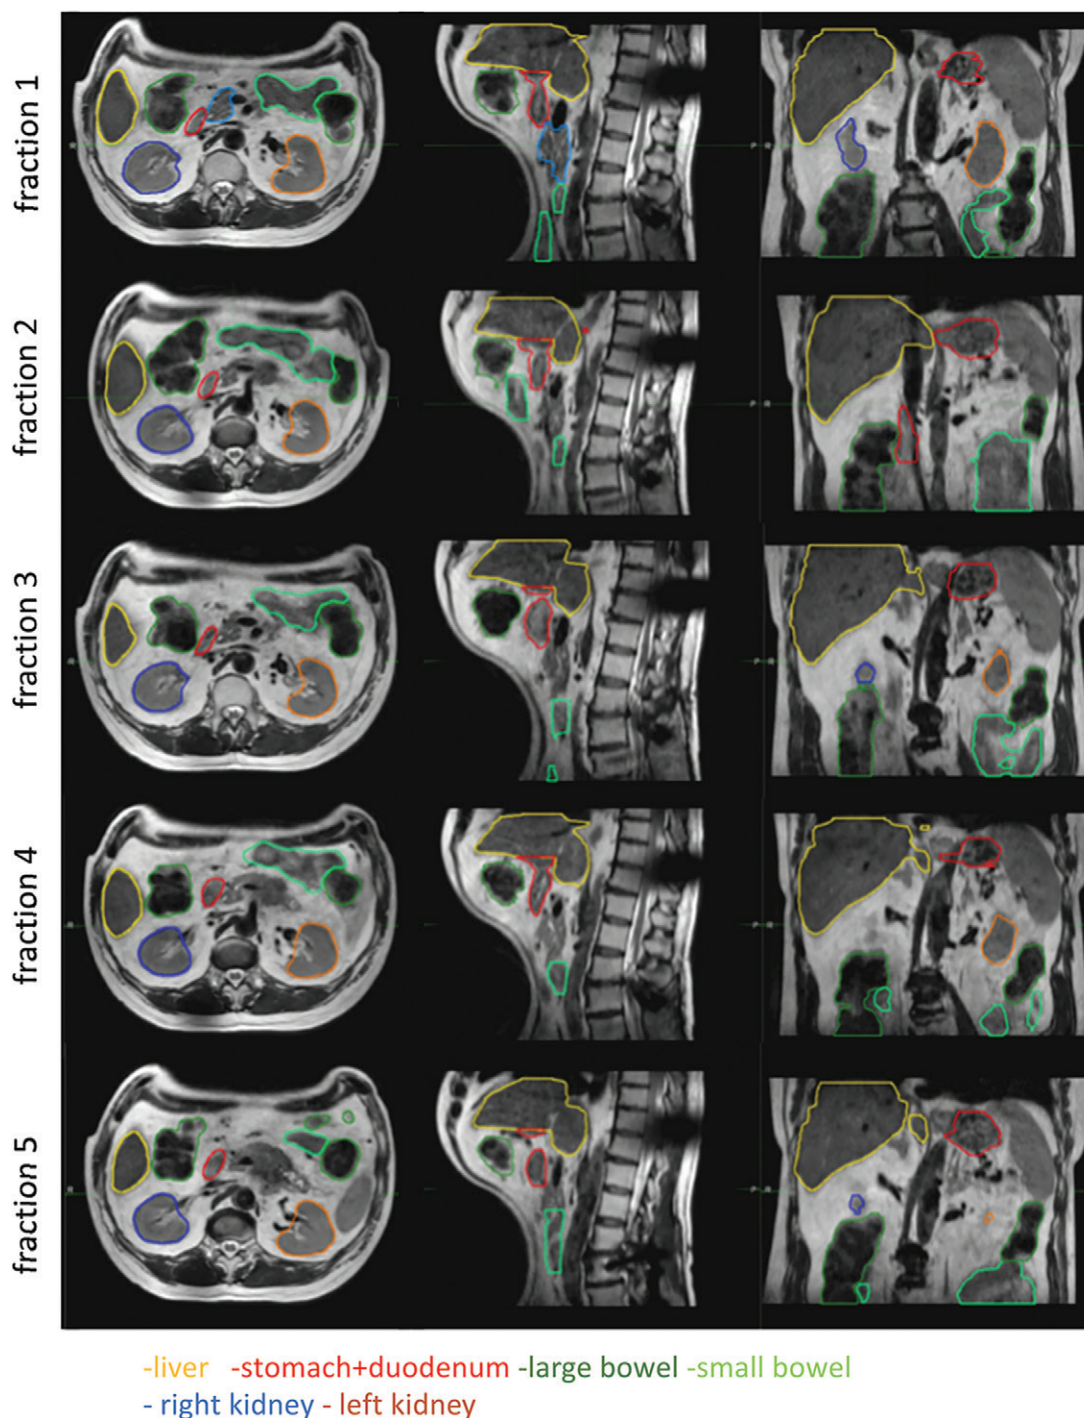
Interfraction motion of organs at risk (liver, bowel, kidney, stomach, and duodenum) in a patient with pancreas cancer undergoing five-fraction stereotactic body radiation treatment (10 Gy \times 5) on the Elekta 1.5-T MRI-guided linear accelerator. The ability to adapt treatment according to the position of the organs at risk increased safety of the procedure. Figure used, with permission, from Dr Neelam Tyagi, Memorial Sloan-Kettering Cancer Center.
